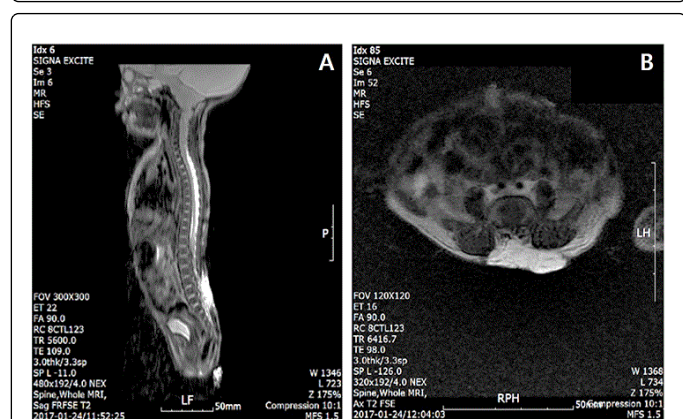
Spine MRI showing the lumbosacral myelomeningocele. A: Sagittal view, B: Transverse view.
